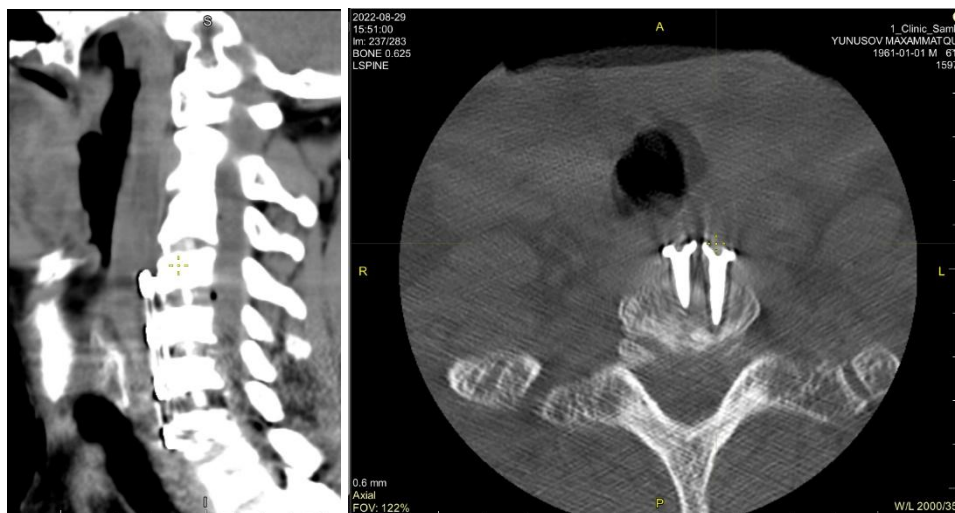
Patient M. August 29, 2022. Multispiral computed tomography of the cervical vertebrae. Stabilization of instability of the cervical spine, complete decompression of the spinal canal, satisfactory fixation with PEEK cage and Plate system, 1 week after surgery.
